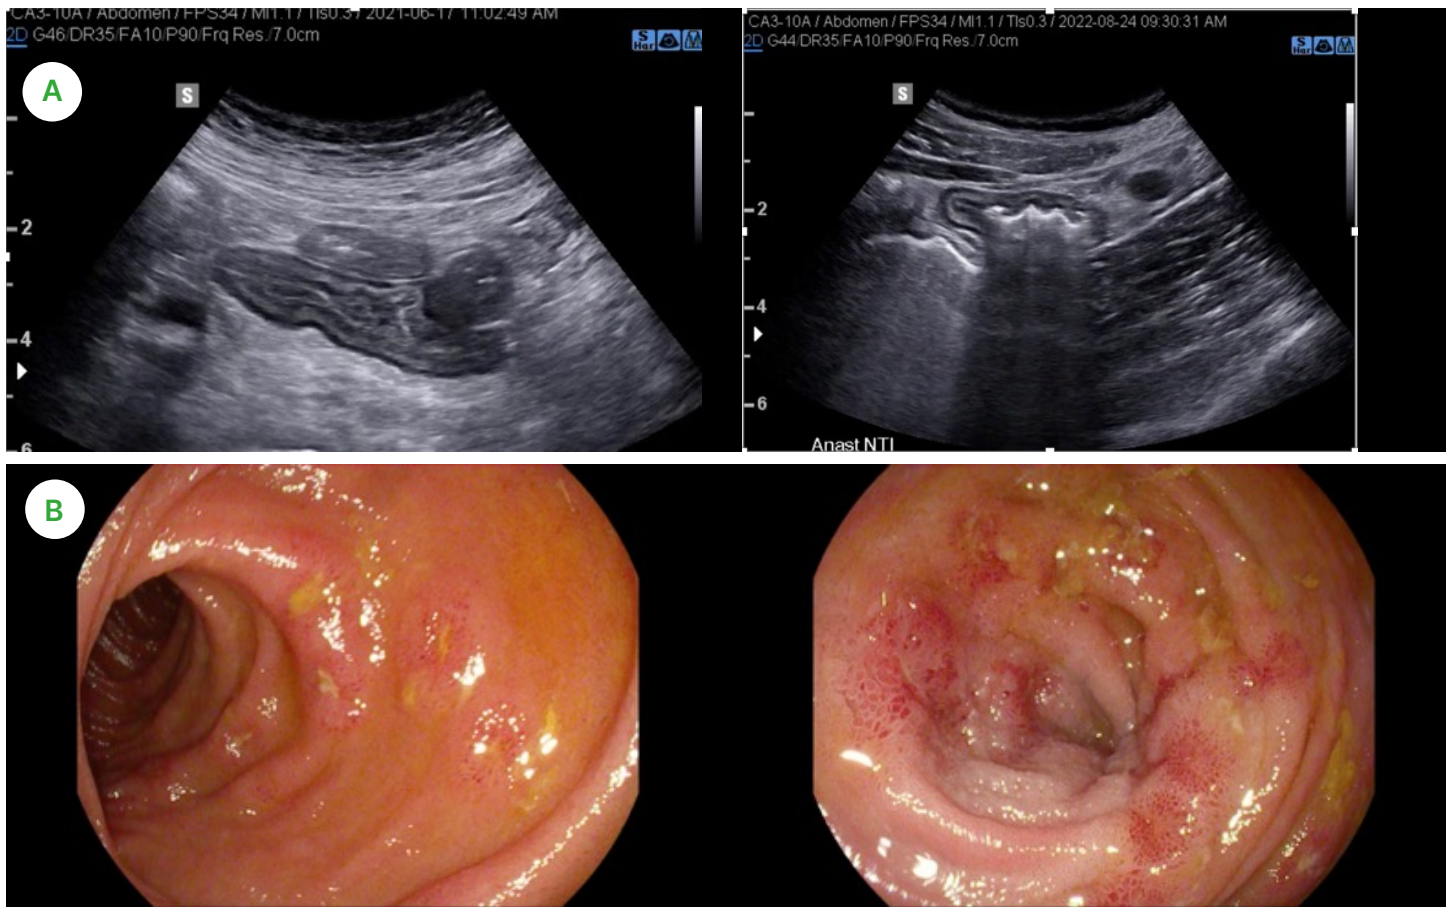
Postoperative Crohn's disease assessment 6 months post-ileocecal resection with side-to-side anastomosis in high-risk patient on postoperative prophylactic biologic therapy. A. Intestinal ultrasound showing side-to-side anastomosis with normal colonic mucosa and increased bowel wall thickness on the ileal side with surrounding bright inflammatory fat. B. Endoscopic images confirmed Rutgeerts score 3 recurrence in the neo-terminal ileum; *courtesy of Dr. Kerri Novak.*
